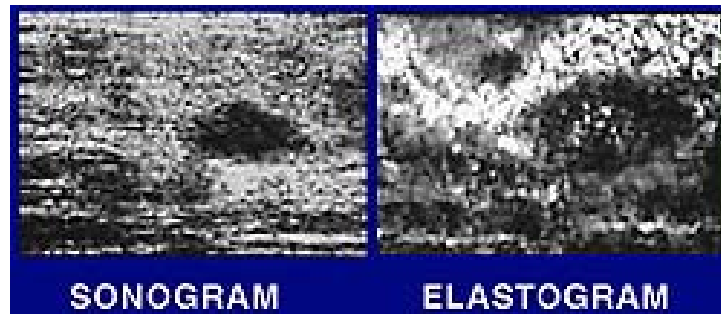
These cross-sectional images were taken from a cranio-caudal scan of a breast of a volunteer patient using a modified Dasonics Spectra™ ultrasound scanner operating with a 5 MHz transducer array. The sonogram and the corresponding elastogram were taken simultaneously from the identical anatomical site. The sonogram shows the presence of a solitary hypoechoic (echo-free, or dark) lesion. The elastogram displays the hard tissues as dark, and the soft tissues as light. It shows the same lesion as being hard (typical of most breast cancers) and larger, most likely due to desmoplasia that causes hardening only around cancerous lesions. It also shows a soft core, suggestive of a necrotic center. Additionally, a second small (~6mm) lesion is detected on the elastogram at 10 o'clock relative to the main lesion. The elastogram ability to display the smaller lesion demonstrates its capability of detecting tumors in earlier stages of development (Ophir,1998)
